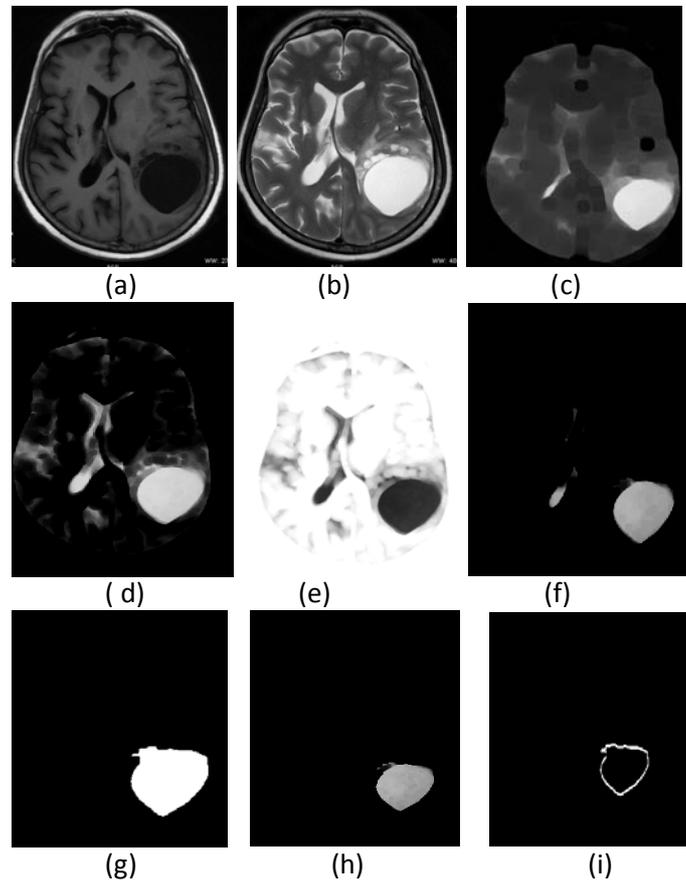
The various steps for segmentation tumor and boundary a)T1 FLAIR b) T2 weighted c) Skull removed d) Subtracted and dilated e) Complemented image f) Intensity adjusted image g) Thresholded and labeled image h) Segmented gray level tumor i). Tumor boundary
